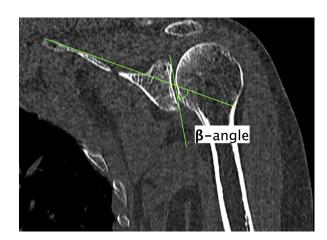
The β -angle as measured on unformatted CT scan of the shoulder.
